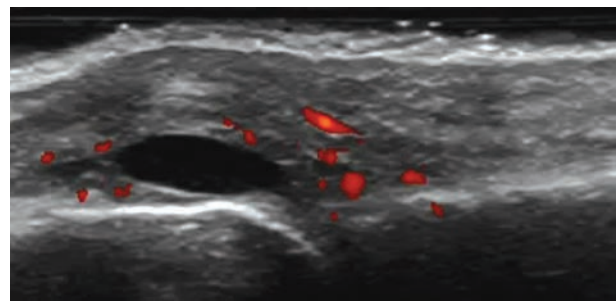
Ultrasound of the II metacarpophalangeal joint in a patient with SSc, demonstrating the presence of joint effusion, synovial hypertrophy and pathological vascularization at power Doppler assessment; these findings are indicative of active synovitis
